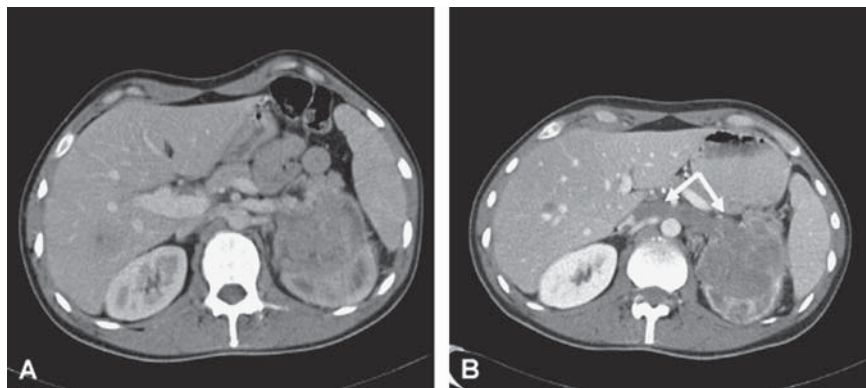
CT scan of the primary tumour of the second patient at baseline (A) and after two cycles of sunitinib demonstrating a newly formed thrombus in the caval vein (arrows) (B).
